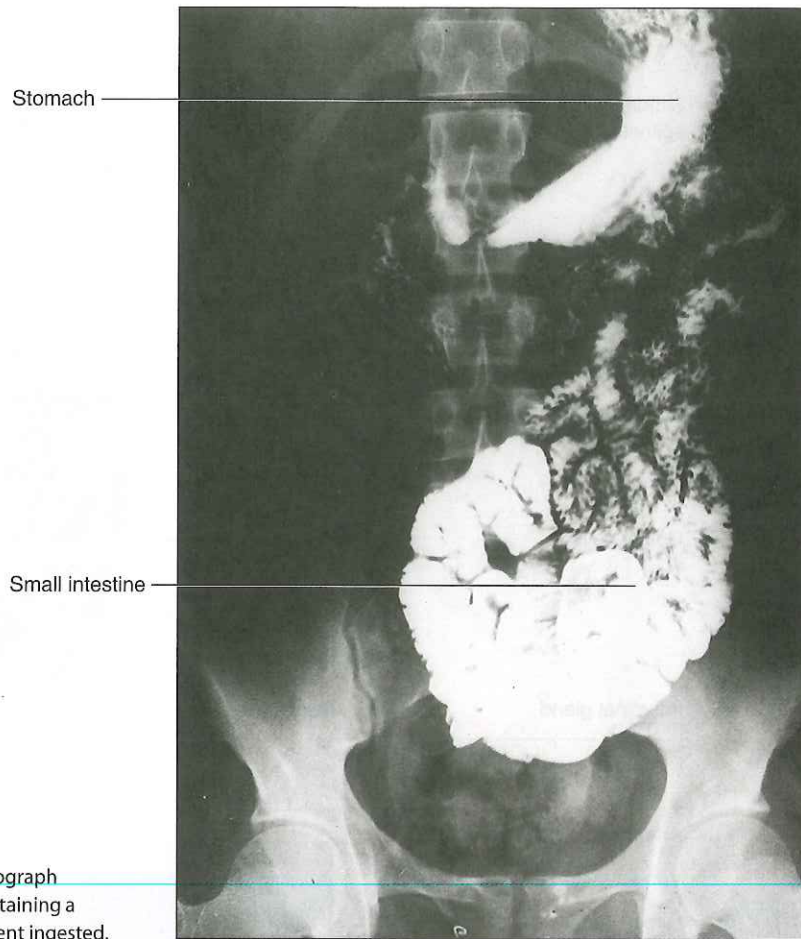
AP|R Radiograph showing normal small intestine containing a radiopaque substance that the patient ingested.
